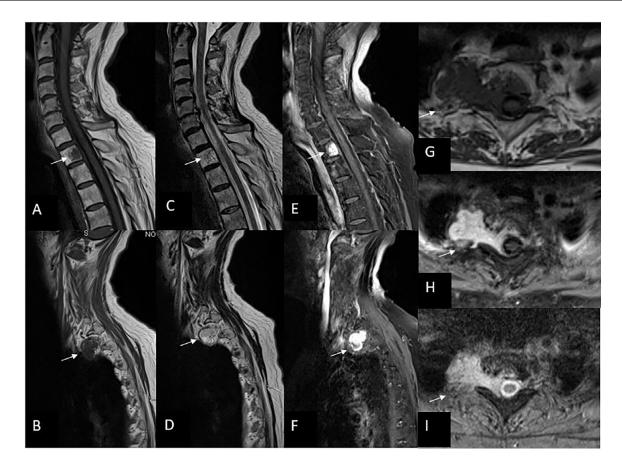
A 24-month follow-up MRI showing further reduction in the size of the mass, arrowed, at the right T1-T2 vertebral level. T1-TSE on (A) sagittal midline, (B) right parasagittal, and (G) axial planes; T2-TSE on (C) sagittal midline, and (D) right parasagittal planes; T1-TSE fat sat postgadolinium on (E) sagittal midline, (F) right parasagittal, and (H) axial planes; and (I) T2-MEDIC on axial plane.
